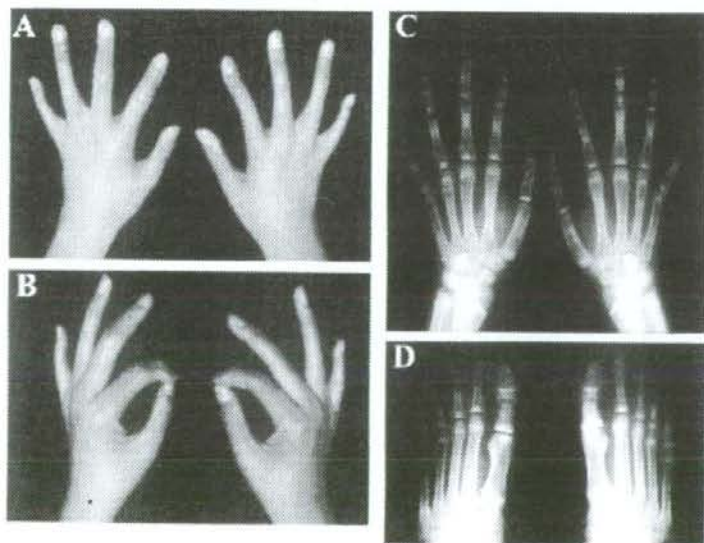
Patient's hands and feet at age 13 years. A: Absence of creases on dorsal surface of proximal interphalangeal joints. B: Limited flexion of proximal interphalangeal joints. C-D: Radiographs showing narrowing and ossiferous adhesion of interphalangeal joints.
